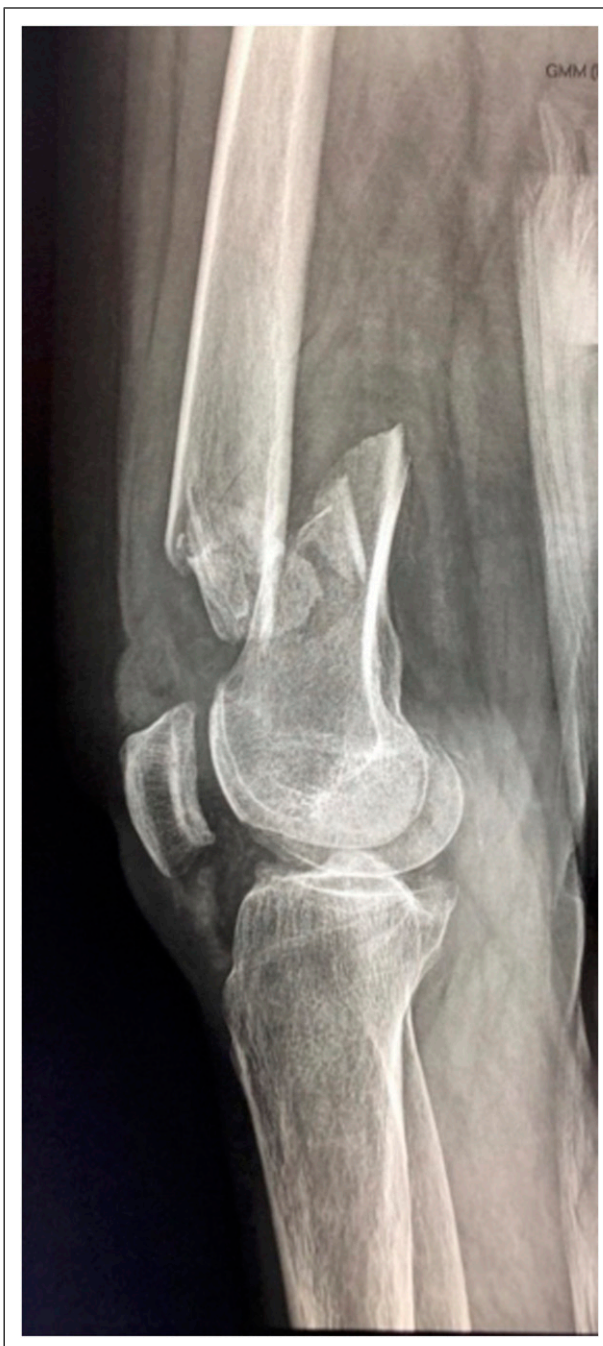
Comminution of fracture (over a well-fixed Zweymueller-type stem, not visible in radiographs) is a minor mechanical criterion, but it can hide impaired biology. The patient was on chronic GSs therapy for myasthenia gravis and presented secondary hypoparathyroidism, too, both due to a thymoma.
